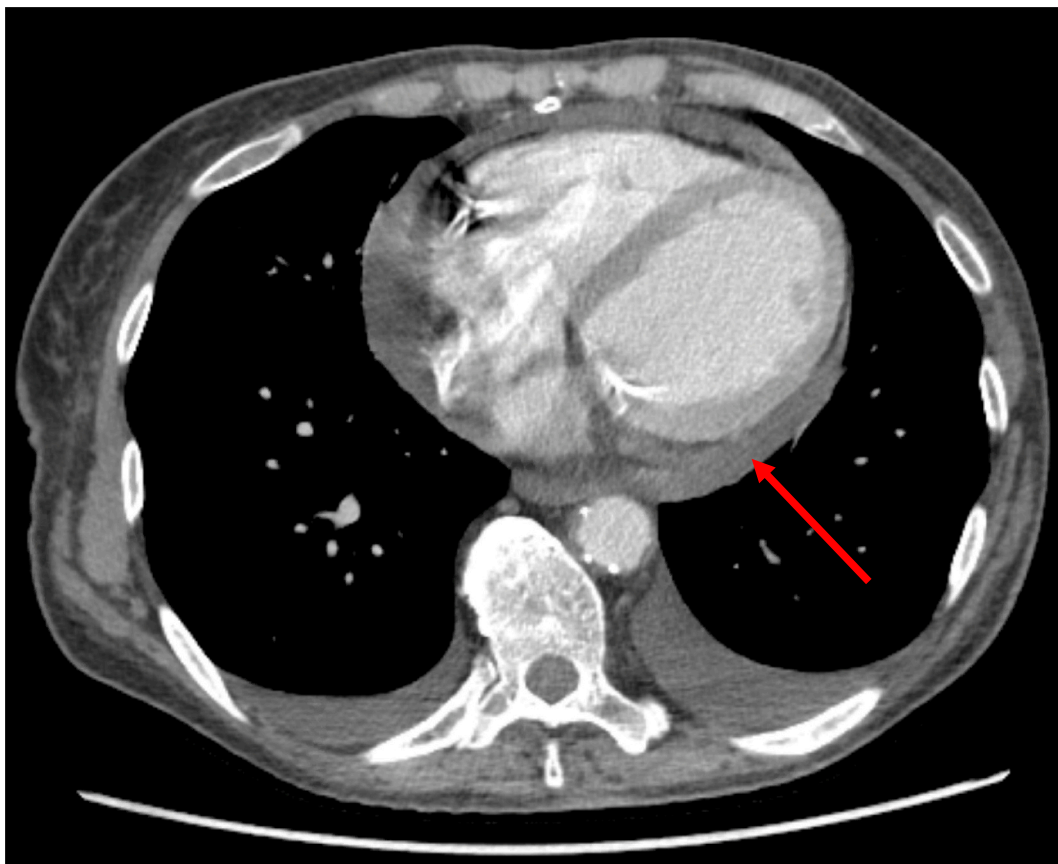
A moderate pericardial effusion demonstrated on computed tomography imaging with interval enlargement since seven months prior.
